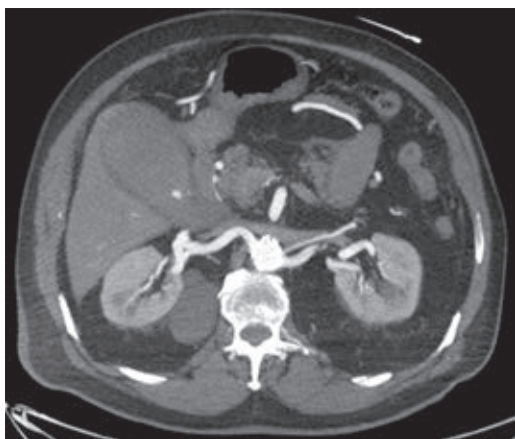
Axial CT scan with arterial phase contrast, showing active bleeding into the gallbladder lumen, which is distended.
